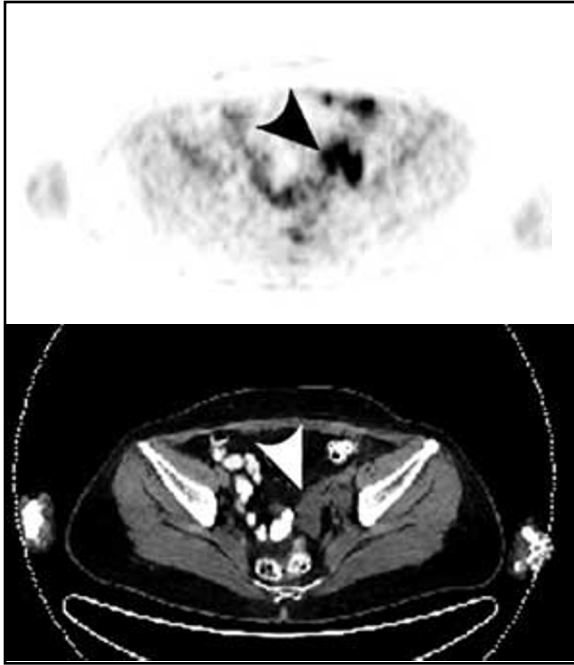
50-year-old woman with ovarian sarcoidosis. PET/CT scan depicts a left adnexal mass (arrowheads) with left internal iliac lymph nodes, both demonstrating increased FDG uptake.
